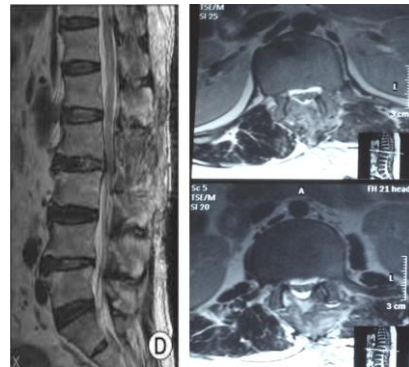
Postoperative MRI T2 axial and sagittal lumbar spine showing L2 total laminectomy and L2-3 discectomy
